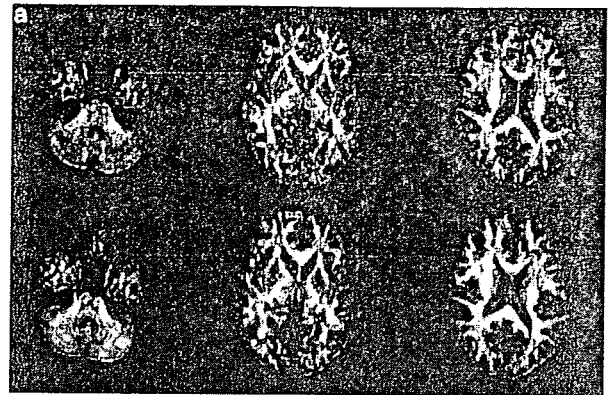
Transverse single-shot spin-echo echo-planar diffusion-tensor MRI at 3 T (TR 5200 ms, TE 79 ms) and 1.5 T (TR 5200 ms, TE 79 ms). (a) Top row shows images of FA obtained at 1.5 T. Bottom row shows images of FA obtained at 3 T. (b) Top row shows images of MD obtained at 1.5 T. Bottom row shows images of MD obtained at 3 T.
